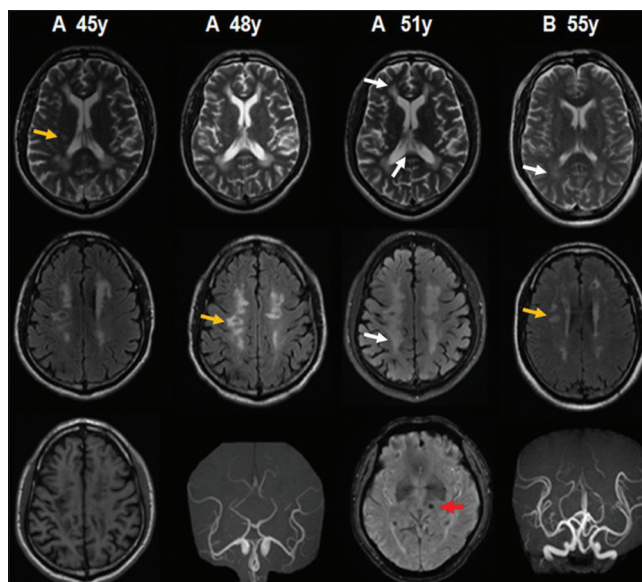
MRI images of proband and II-1. Left three columns: Proband at the age of 45, 48, 51. Right column: II-1 at the age of 55. First line: T2-weighted images. Second line: FLAIR images. Third line: T1-weighted image (A 45y), 3D time of flight image (A 48y, B 55y), gradient-echo image (A 51y). Multifocal cerebral infarction (yellow arrow). White matter hyperintensities (white arrow) involve corona radiata, bilateral periventricular and corpus callosum. Microbleeds (red arrow). No atherosclerosis are detected
